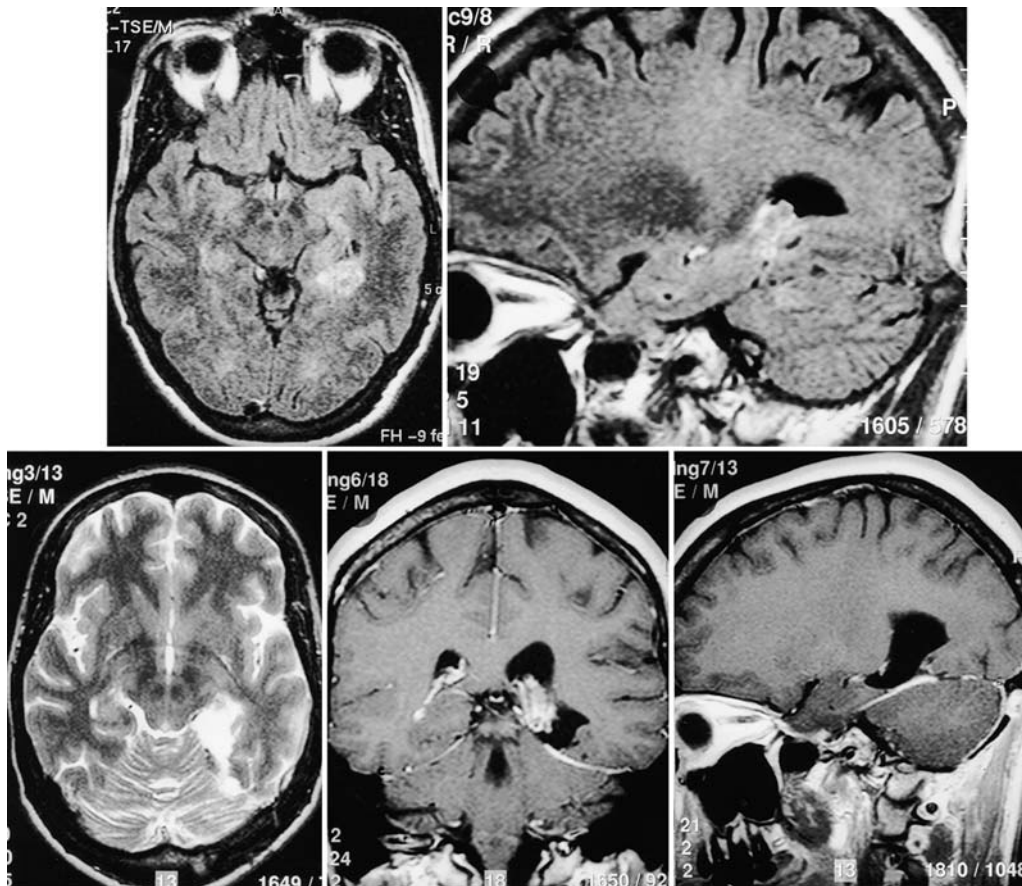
Case 3. Imaging studies obtained in a 37-year-old woman in whom a low-grade astrocytoma was located in the posterior hippocampus. Axial (upper left) and sagittal (upper right) MR images revealing a space-occupying lesion. Follow-up CT scan (lower left) and coronal (lower center) and sagittal (lower right) MR images confirming complete removal of the mass along with removal of the posterior hippocampal formation.
